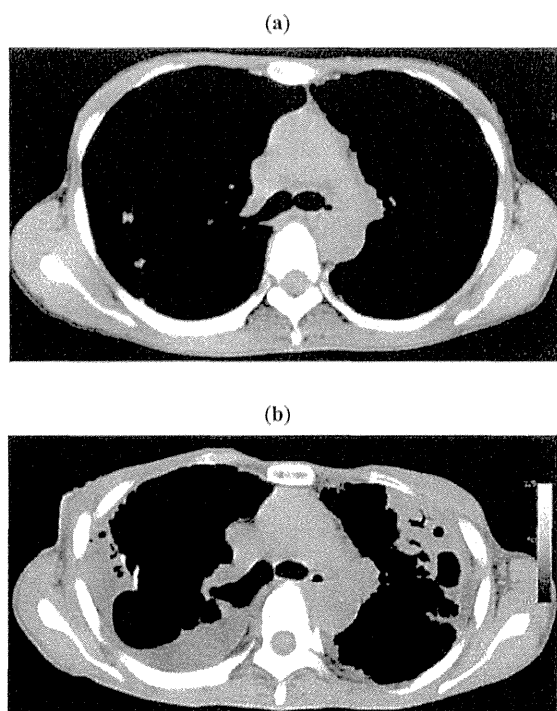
(a) Chest CT in a 48-year-old woman with PPFE. (b) Chest CT taken after 4 years. Both CT scans were sliced at the level of the 6th thoracic vertebra. The ratio of the anterior–posterior diameter of the thorax to the transverse diameter of the thorax became lower after 4 years of disease progression.
